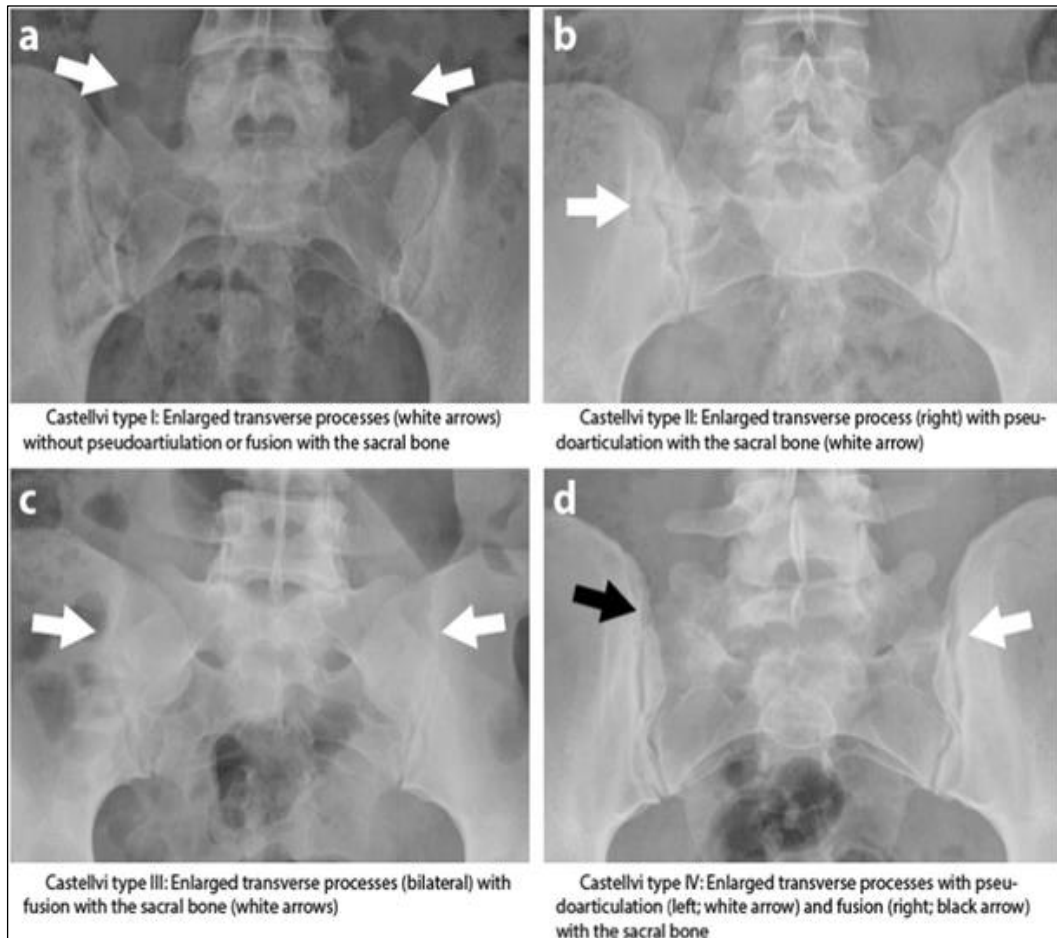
Representative Radiographs of different types of LSTV
